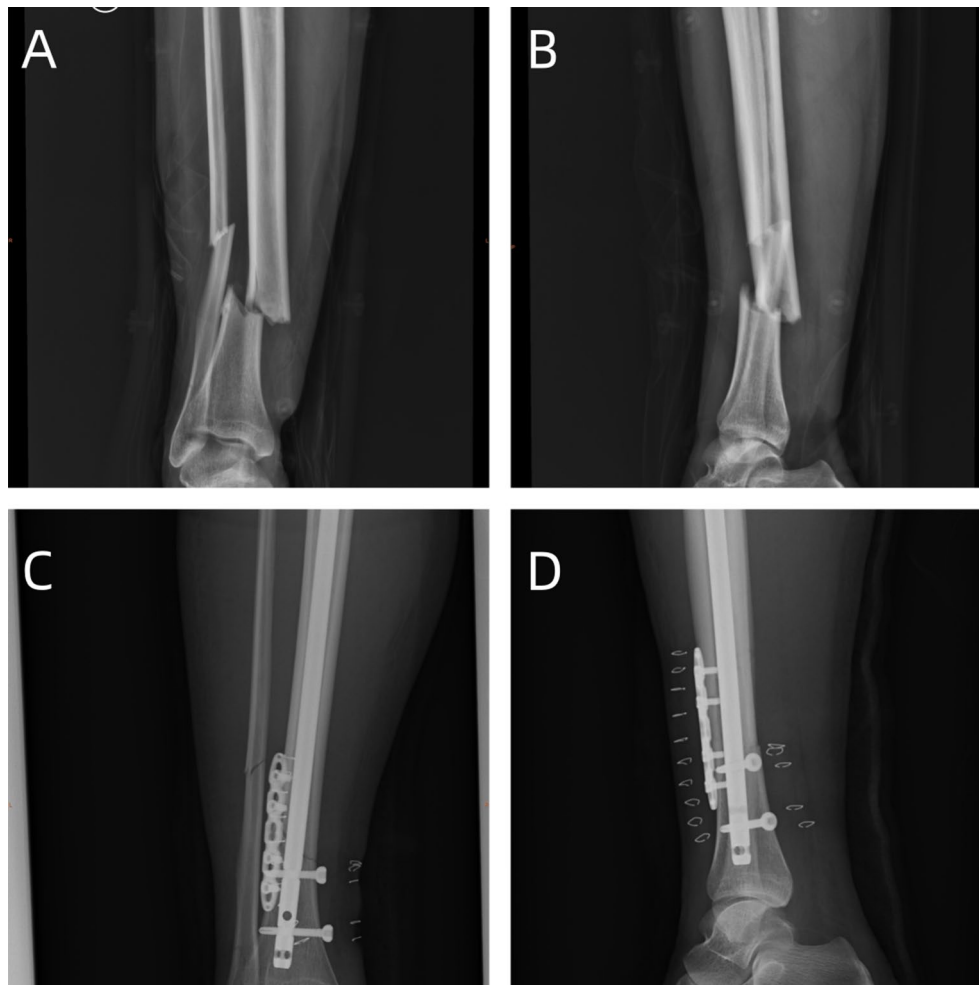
A case of distal tibia fracture combined with a reconstruction plate. (A-B) A 47-year-old female patient with a closed distal tibia fracture. AP and lateral preoperative X-rays. (C-D) This patient initially underwent an attempt at closed reduction via the infrapatellar approach, but intraoperatively, the closed reduction failed to achieve satisfactory alignment. Consequently, the procedure was changed to open reduction with the assistance of a reconstruction plate. AP and lateral postoperative X-rays
